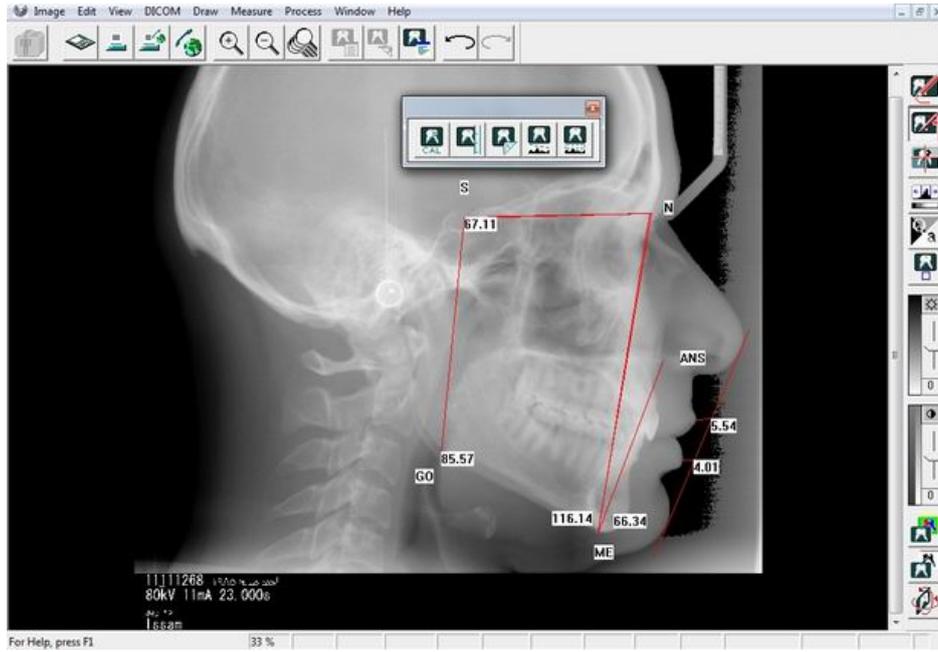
Linear cephalometric analysis of compressed radiographic digital image to the 60% of the original size.
